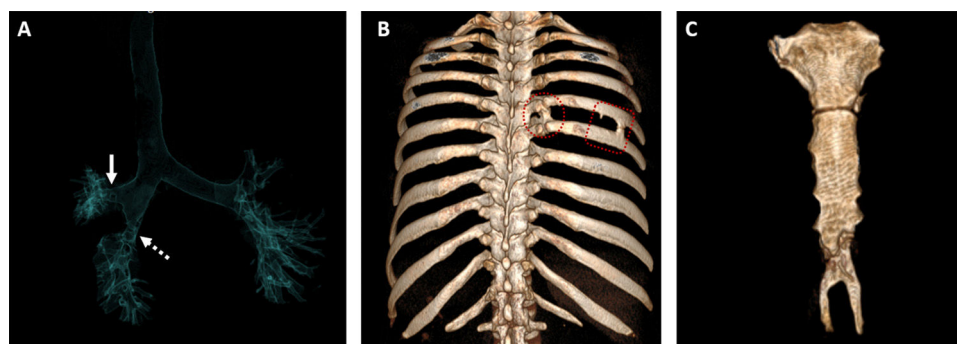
(A) Coronal anterior projection air specific volume rendering 3D CT image shows a normal right upper lobe bronchus (arrow) and narrowed lower lobe bronchus (dashed arrow), but there is not middle lobe bronchus. (B) Posterior view 3D volume rendered CT image reveals fusion anomalies (frames) in multiple segment between fifth and sixth ribs. (C) Anterior view 3D volume rendered CT image shows a giant forked shaped xiphoid of the sternum.
